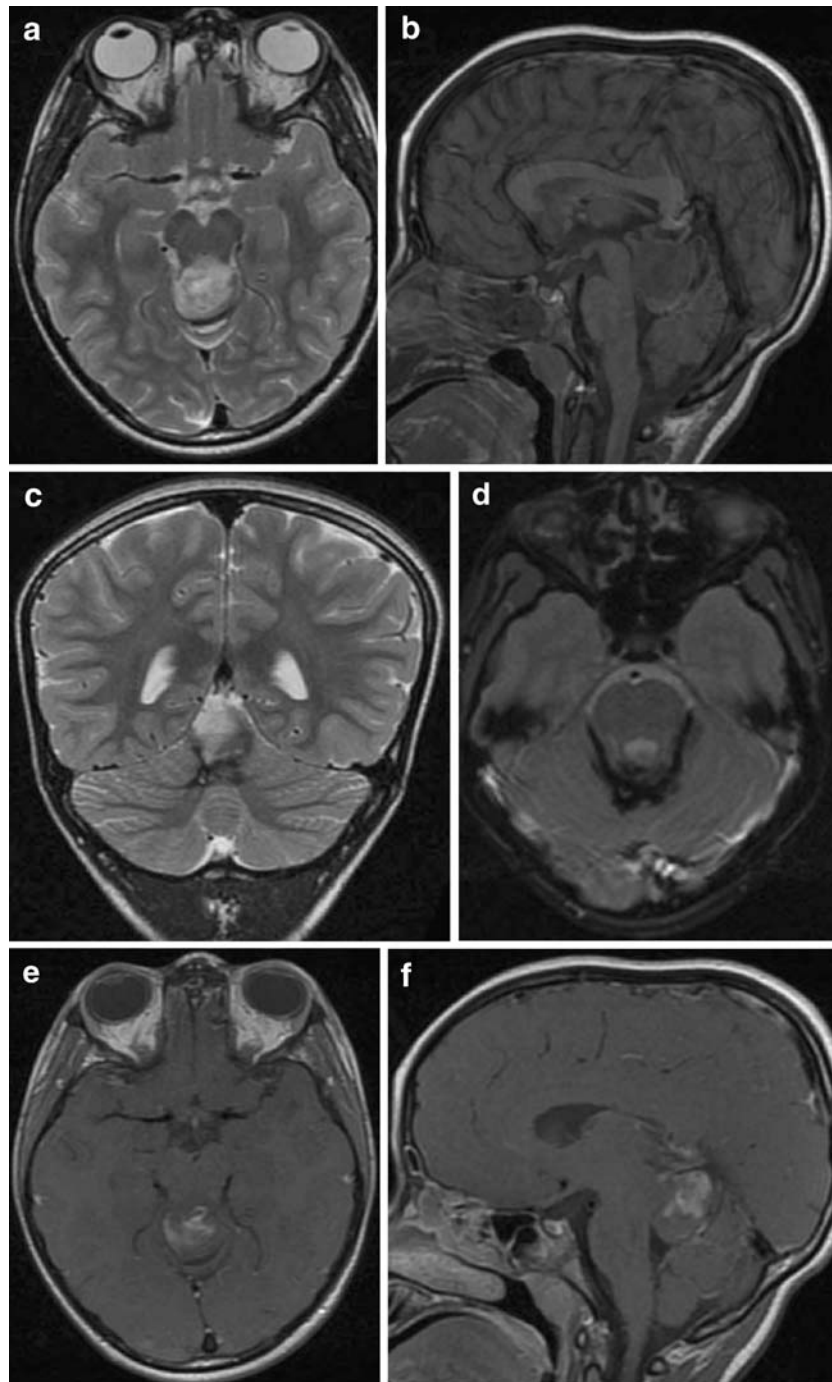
Preoperative MR imaging. Axial T2-weighted (a), sagittal T1-weighted (b), and coronal T2-weighted sequences (c) showing the tumor arising from the posterior part of the quadrigeminal plate and extending up to the superior vermis. The lesion shows a dishomogeneous signal on both T2 (hyperintense) and T1 sequences
